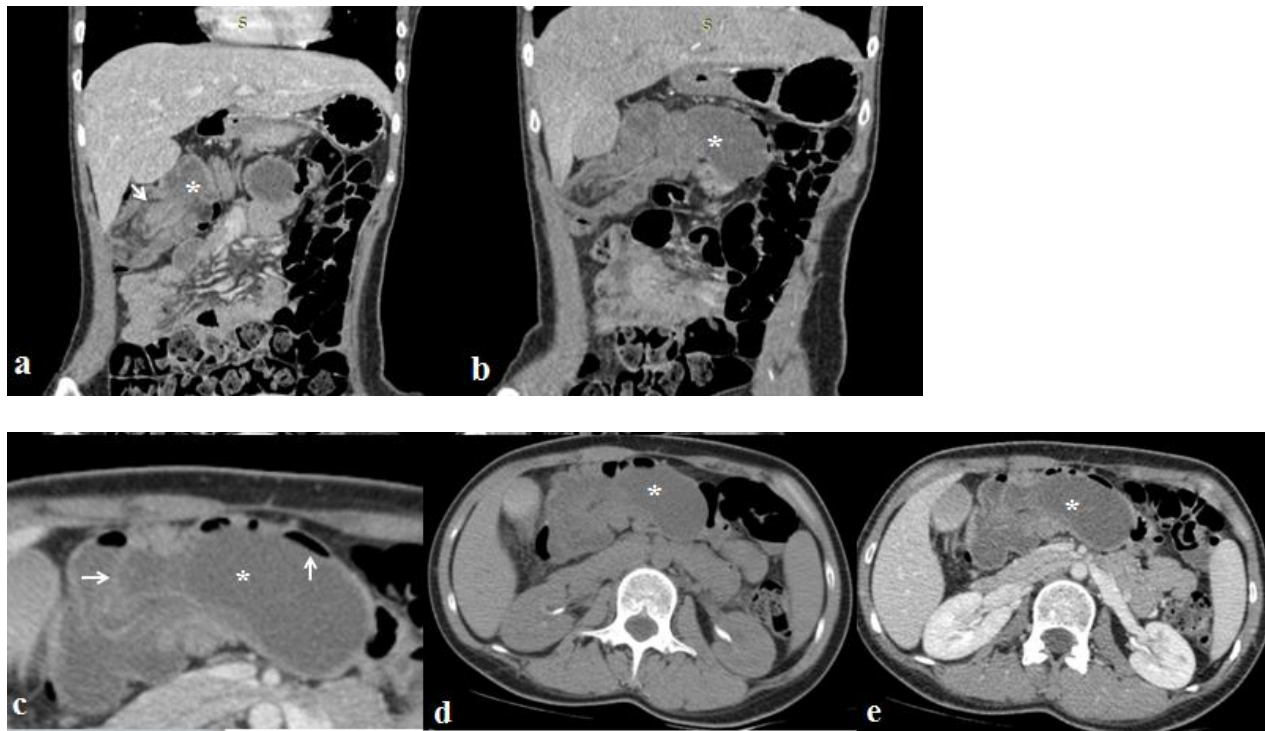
Computed Tomography (CT) scan of the abdomen with contrast injection.
